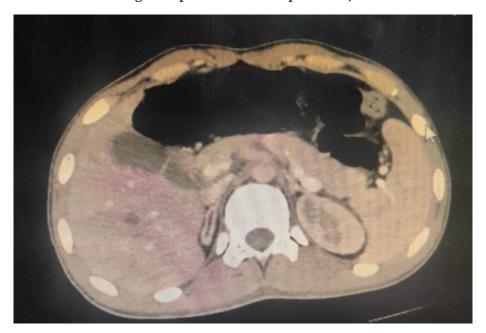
CT abdomen showing bulky pancreas with minimal ascites
